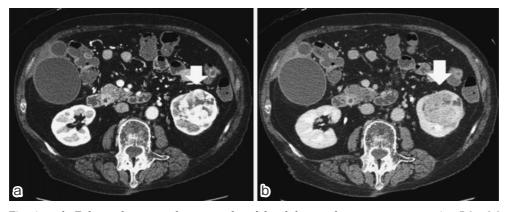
a, b: Enhanced computed tomography of the abdomen shows a mass measuring 5.8×3.0 cm in the left kidney. The mass was strongly enhanced in the early phase and washed out in the late phase (arrow).
